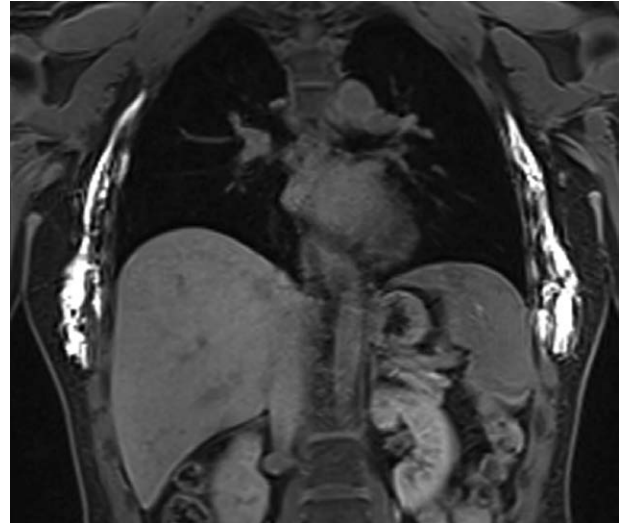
Sagittal MRI demonstrating subserratus block.
